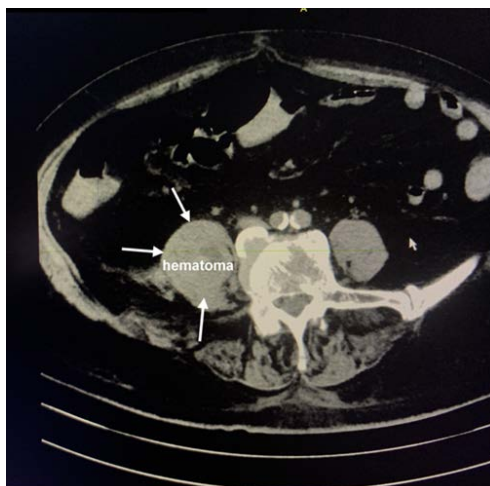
CT picture (with intravenous contrast) of hematoma of the right iliopsoas muscle: there is an increase in the size of m. iliopsoas, a hypodense area 23 * 21 * 50 mm is visualized at the L4-L5 level.
